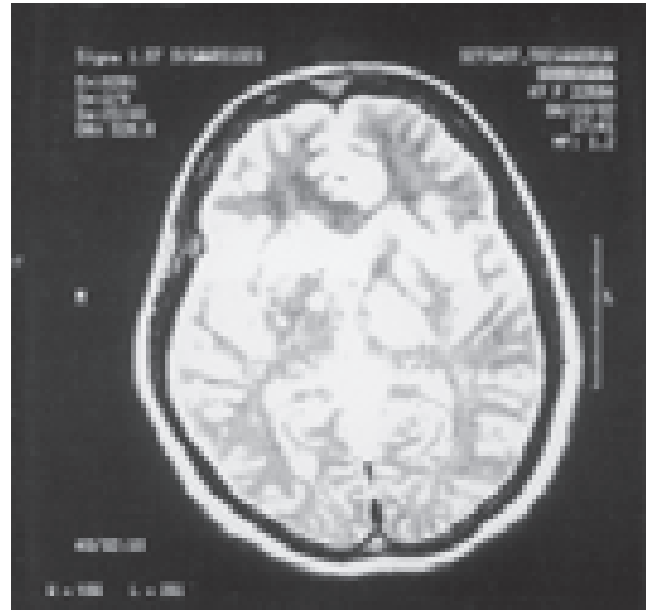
MRI T2 weighted image, multiple plaques in the white matter, both thalami (left more than right) and basal ganglia.
